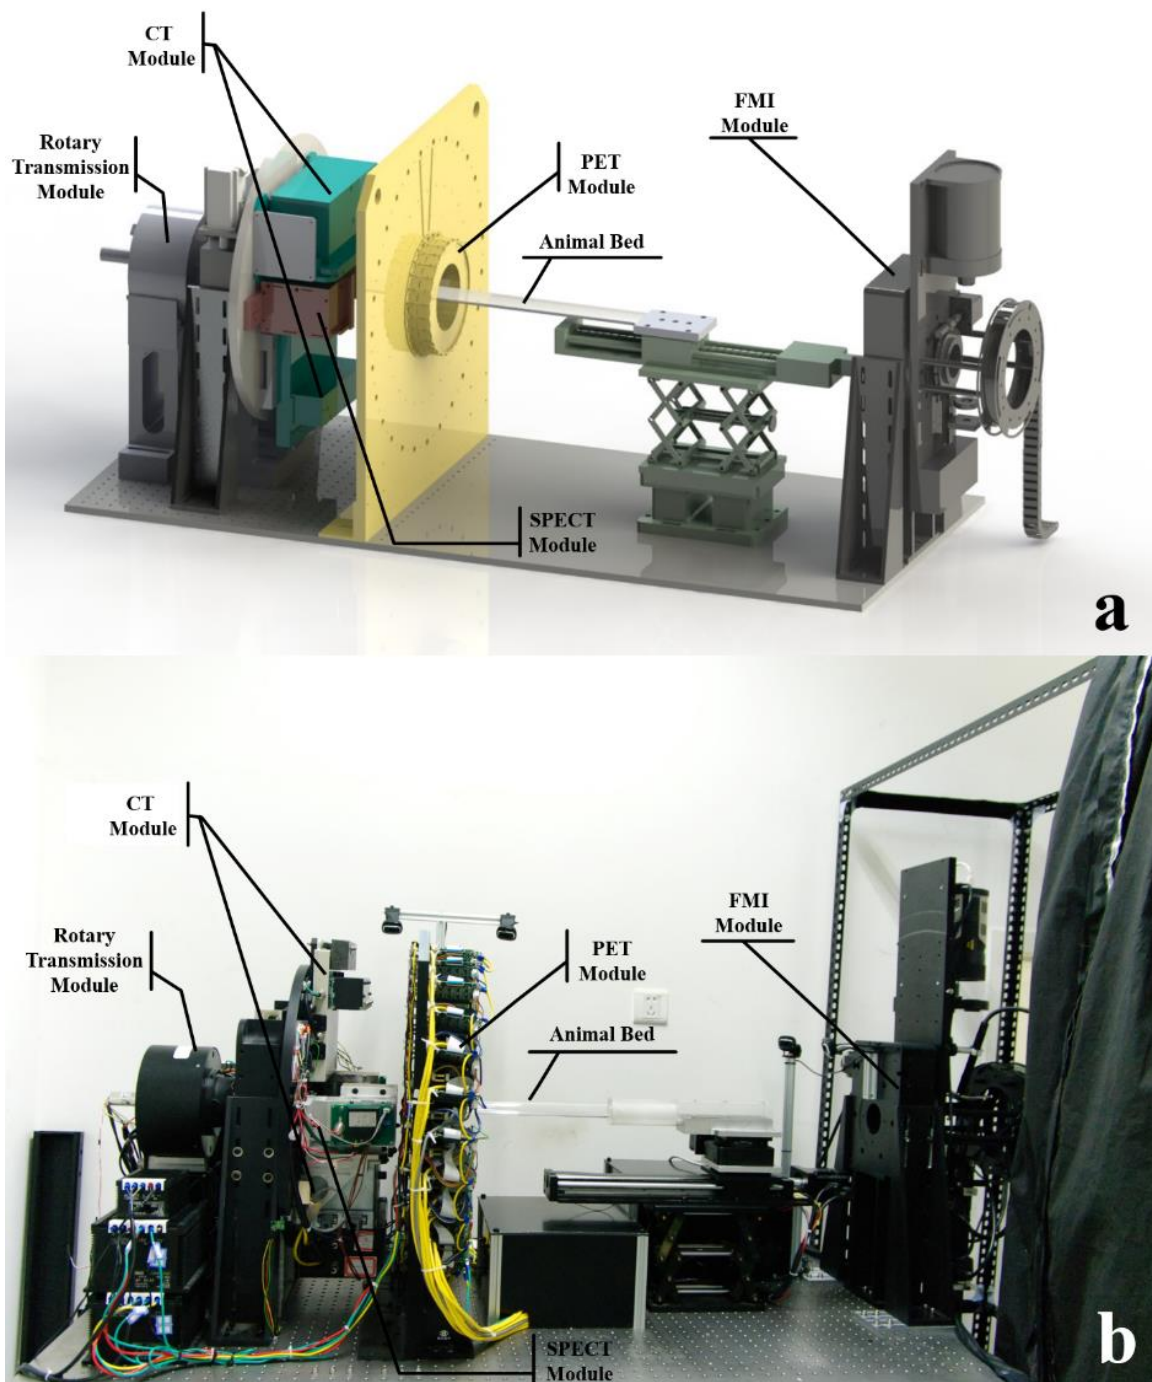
Integration of the Quad-modality imaging system. (a) Draw of quad-modality imaging system, which consisted of the PET, CT, SPECT and FI imaging modules. (b) Photograph of the quad-modality imaging system, which can be setup on an optical table. Reprinted from Lu et al ^[78] with permission. Copyright © 2014 Society of Nuclear Medicine and Molecular Imaging, Inc.
